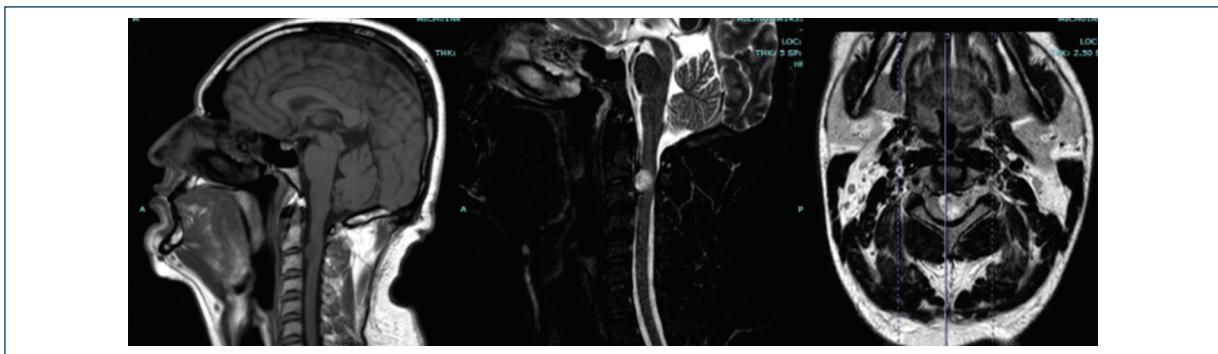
Cervical magnetic resonance imaging showing a compressive mass lesion with a size of 2×2 cm.
